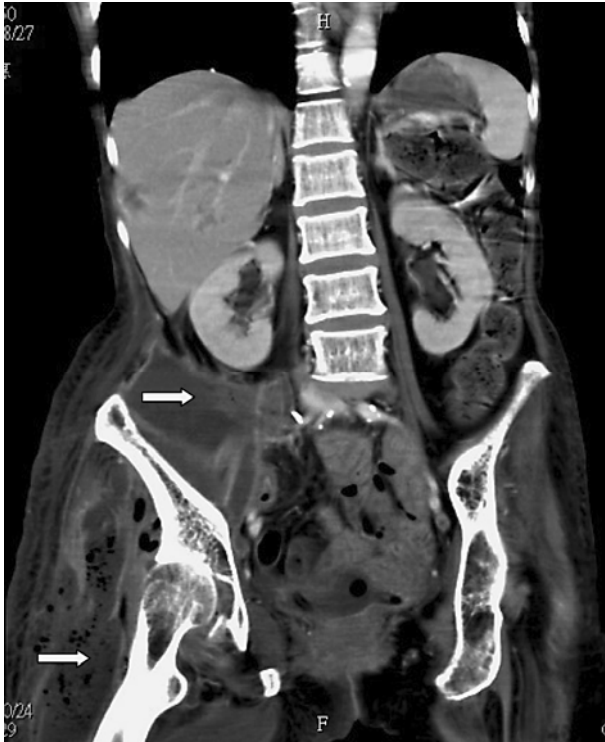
CT scan with contrast of the abdomen showing fluid and gas tracking from the retroperitoneum into the intramuscular plane of the grossly enlarged right thigh.
